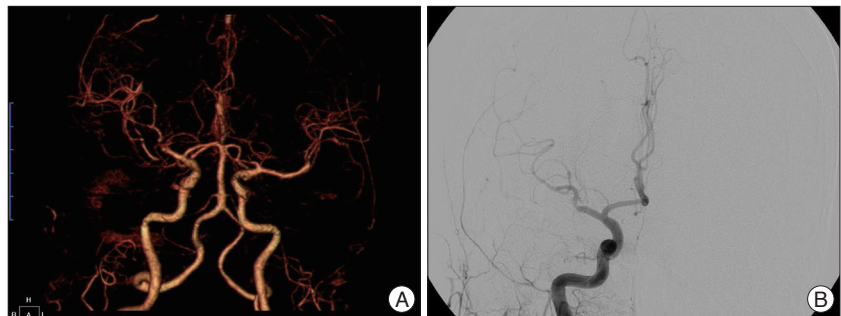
A : Immediate postoperative computed tomography angiography demonstrates good M2 trunk flow of with good patency of the bypass graft. B : Emergency TFCA demonstrates occlusion of the inferior M2 trunk, and no visible bypass pedicle is detected. TFCA : transfemoral carotid angiography.
